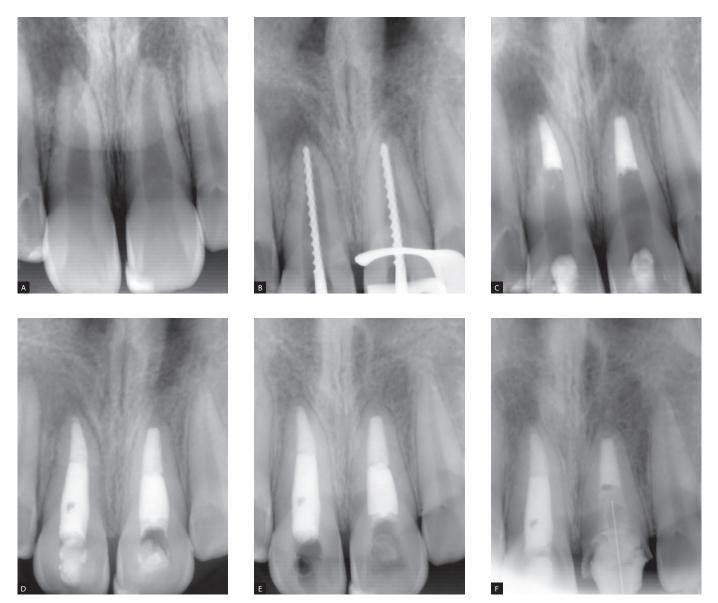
A) Initial periapical radiograph of the maxillary central incisors. B) Odontometry. C) MTA apical plug. D) Final radiograpy after obturation. E) Final radiograpy after obturation. F) Follow-up at 60 months.
